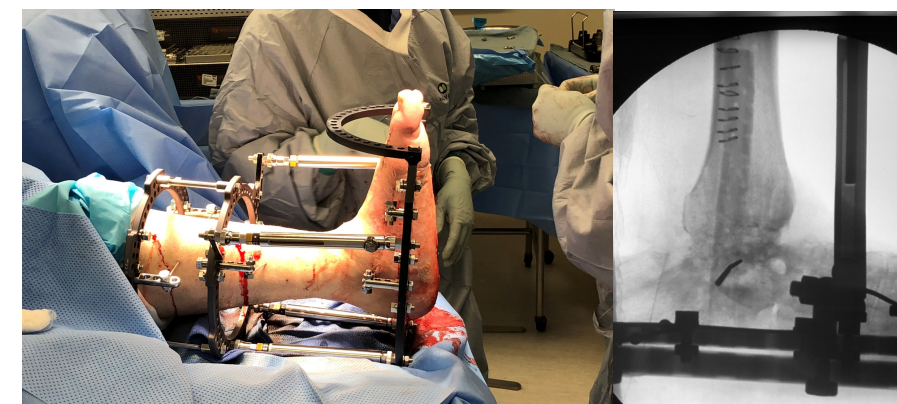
Placement of external fixator shown on left. Right image is radiograph demonstrating intra-medullary fibular placement.
